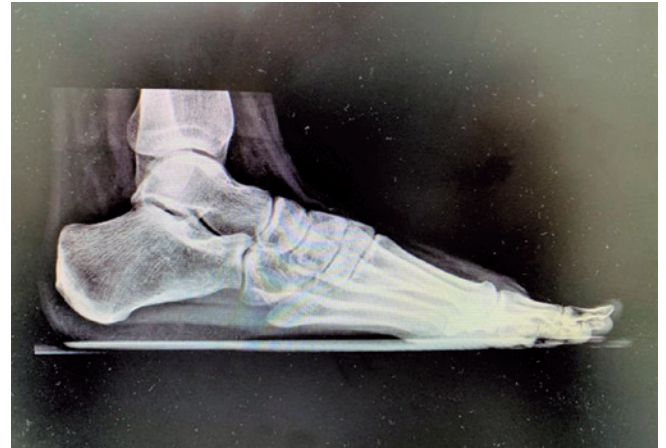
Profile radiograph of the left foot. No lesions were visualized.
